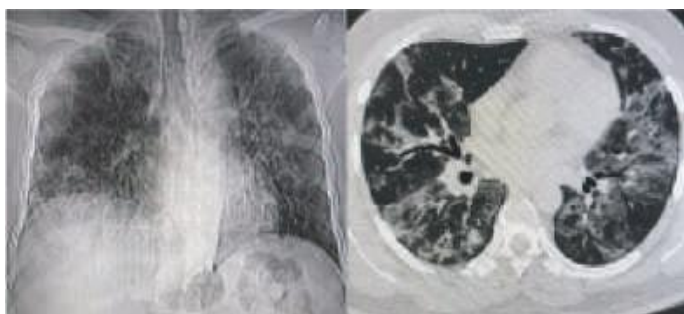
Chest X-ray & HRCT showing subpleural & peribronchovascular ground glass opacities suggesting Atypical Pneumonia
